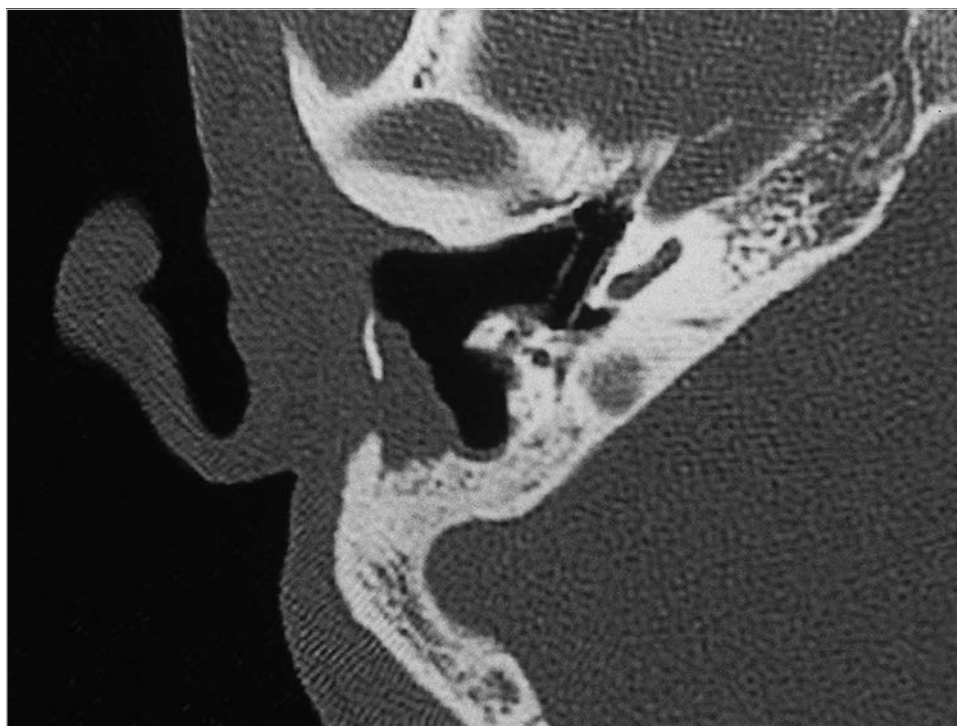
The patient was operated elsewhere, and inflammation of the canal wall down cavity sustained after the surgery. The CT image shows an axial view of the badly performed canal wall down technique with very high facial ridge, and sharp bony overhangs. A Silastic sheeting is seen in the tympanic cavity.
